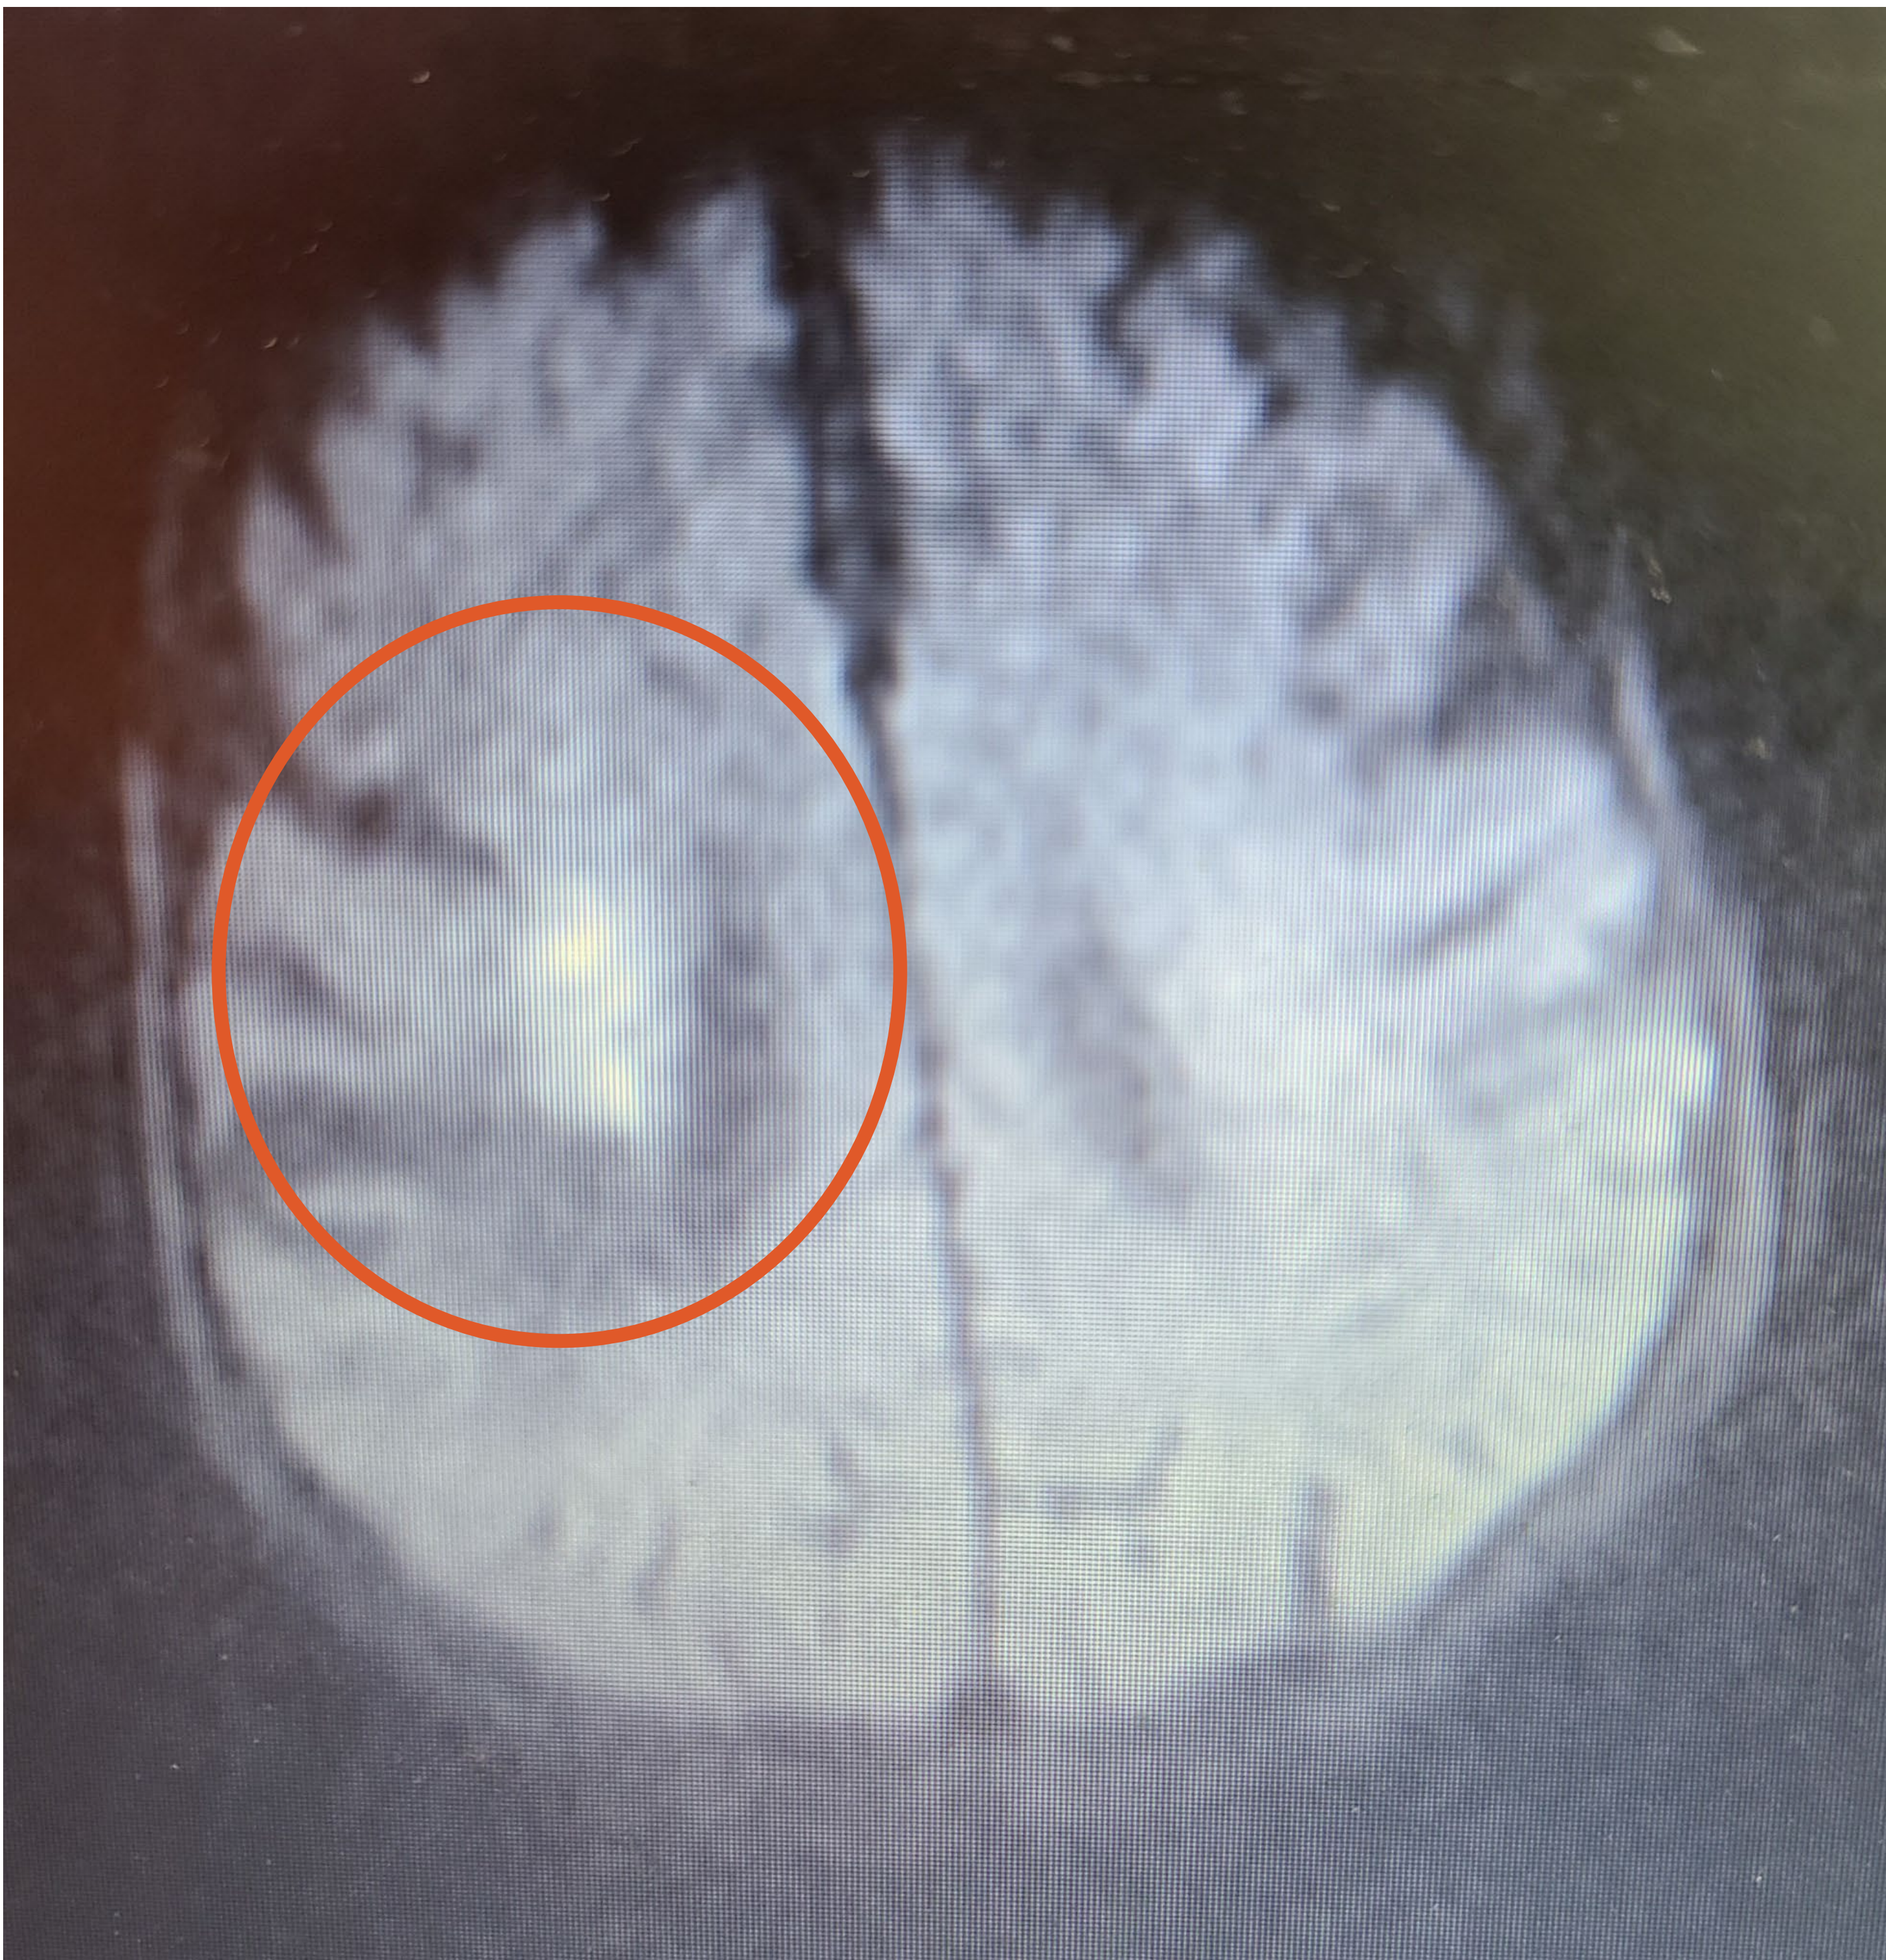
MRI showing acute cerebrovascular nonhemorrhagic ischemia demonstrated involving the right centrum semiovale
